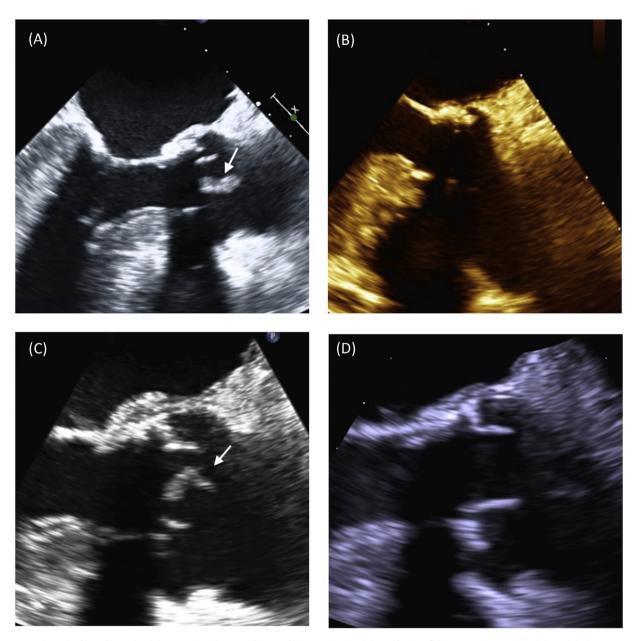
Transesophageal Echocardiography. (A) Vegetation shown on bioprosthetic aortic valve. (B) Resolution of the vegetation one month later (C) Linear vegetation on bioprosthetic aortic valve 3 months after (D) Complete resolution of the vegetation 12 months after.
